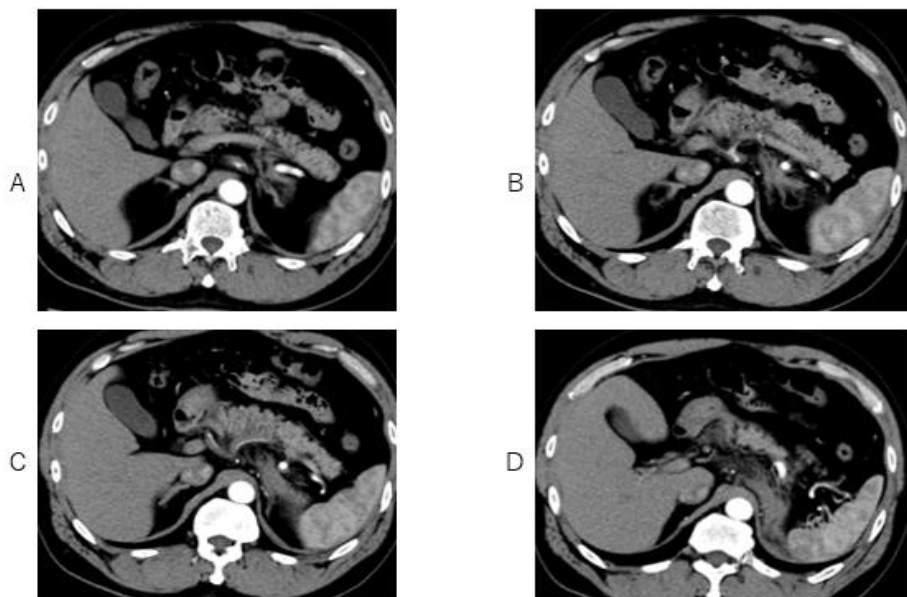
Stenosis of the intravascular lumen of celiac axis, splenic artery, and common hepatic artery is visualized on axial contrast-enhanced CT (A-E).
